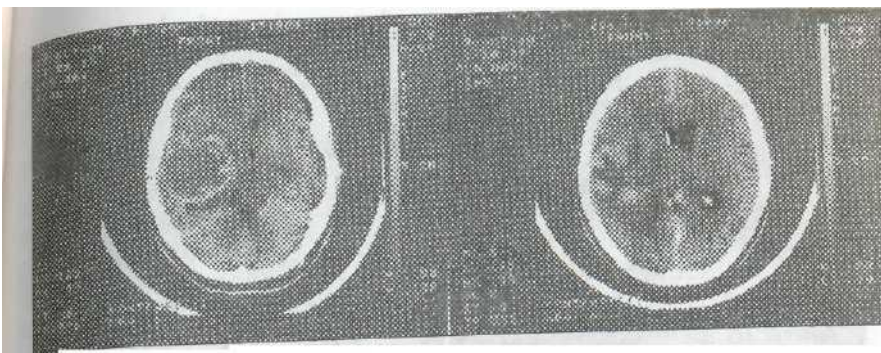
CT. Anaplastic astrocytoma
